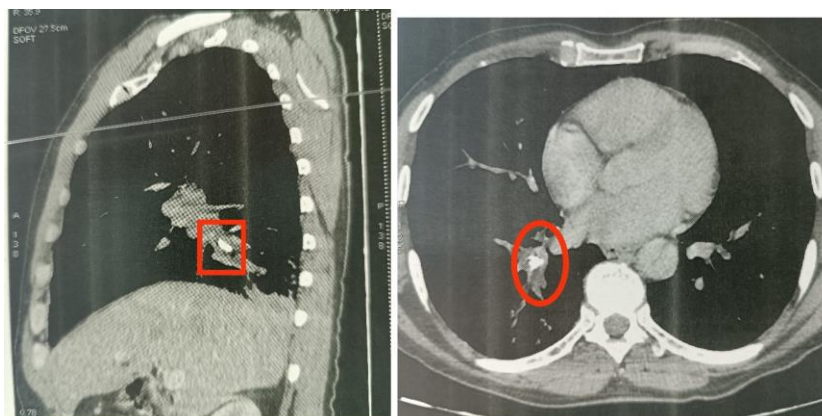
Chest CT showing a calcified foreign body in the right lower lobe, accompanied by alveolar consolidation extending into the postero-basal segment.
